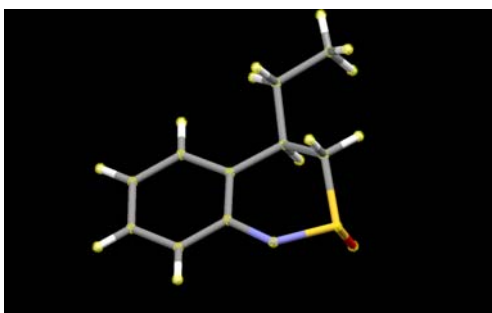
X-ray Structure of 539
